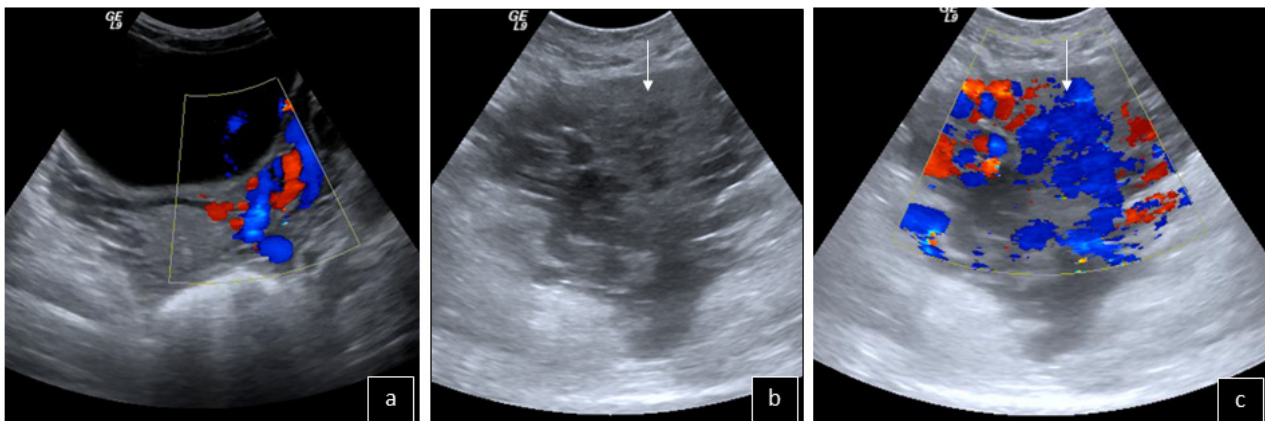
Different cases of pelvic congestion syndrome: a. Serpiginous blood vessels with increased flow are seen next to the left ovary on colour Doppler US. b, c. Serpiginous veins are present in both ovaries, extending to the uterus (arrows) on B-mode (b) and colour Doppler (c) US.
